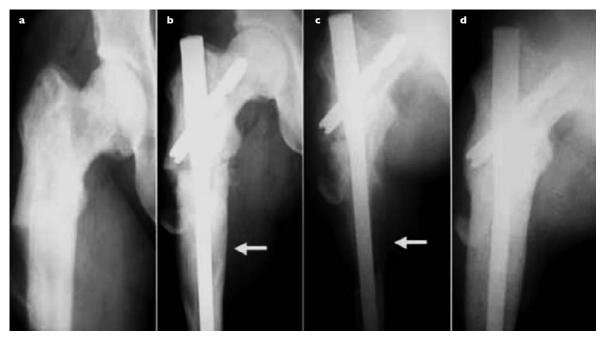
Case 2. Serial radiographs show: (a) pathological subtrochanteric fracture of the left femur in typical Paget's disease; (b) early osteolysis distal to the fracture (3 cm \times 2 cm) at four weeks follow-up; (c) extensive osteolysis at eight weeks follow-up; (d) complete reversal of osteolysis at 22 weeks.
